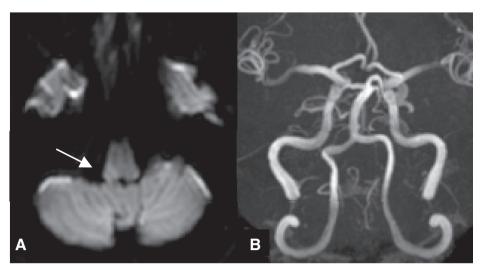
MRI on the initial consultation. (A) DWI revealed an infarcted focus on the lateral side of the right medulla oblongata (solid arrow). (B) MRA showed no wall irregularity in the left or right vertebral arteries. DWI: diffusion-weighted imaging
